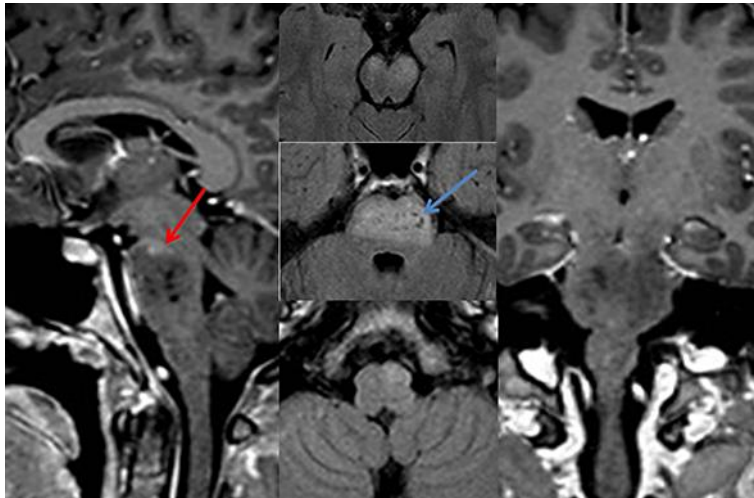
Sagittal (left column) and coronal (right column) post-contrast T1WI show an extensive hypointense lesion located in both cerebral peduncles and ventral pons with a faint enhancement centered at the top of the pons (red arrow). Axial-FLAIR images in the middle column (from top to bottom: mid-brain, pons and medulla oblongata) show an extensive hyperintense lesion mainly located in the ventral pons. There is also a hyperintense image at the left inferior olivary nucleus. The main lesion shows a mild expansion and cystic changes (blue arrow).
